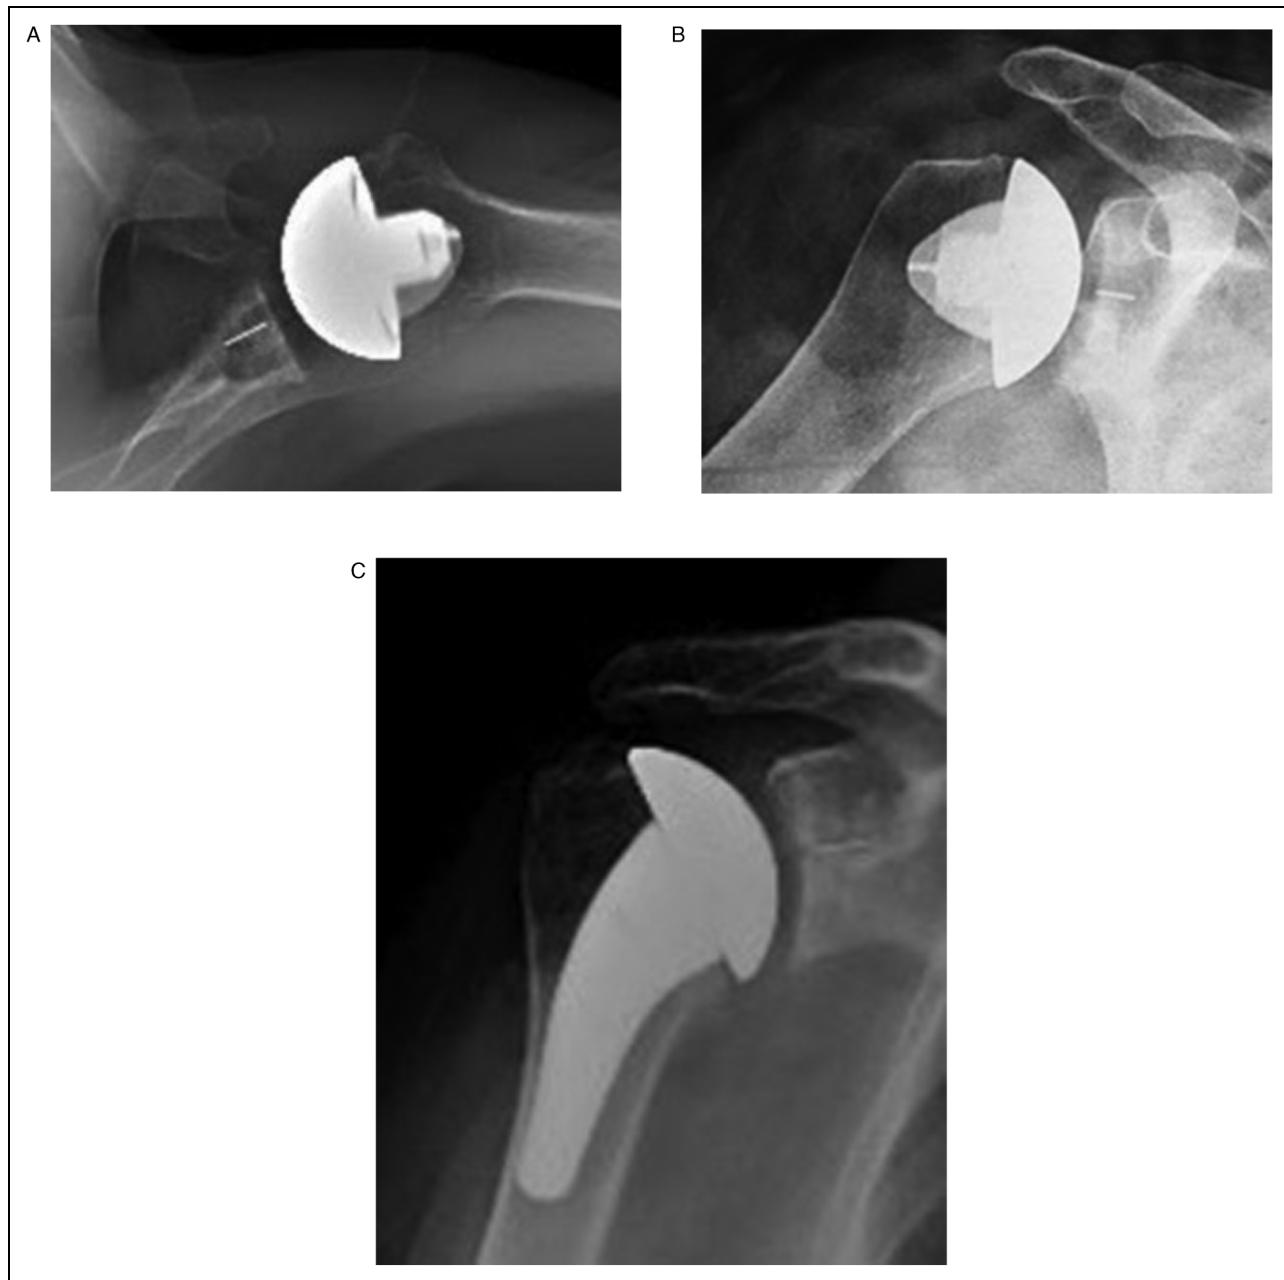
(A) Axillary radiograph demonstrating a glenoid component with a 15° posterior augment. (courtesy Michael T. Freehill). (B) Grashey radiograph demonstrating a stemless design humeral component with a nucleus stem and a non-soft tissue balancing humeral head component. (courtesy Michael T. Freehill). (C) Grashey radiograph demonstrating stemmed and high-offset humeral head components. (courtesy Michael T. Freehill).
